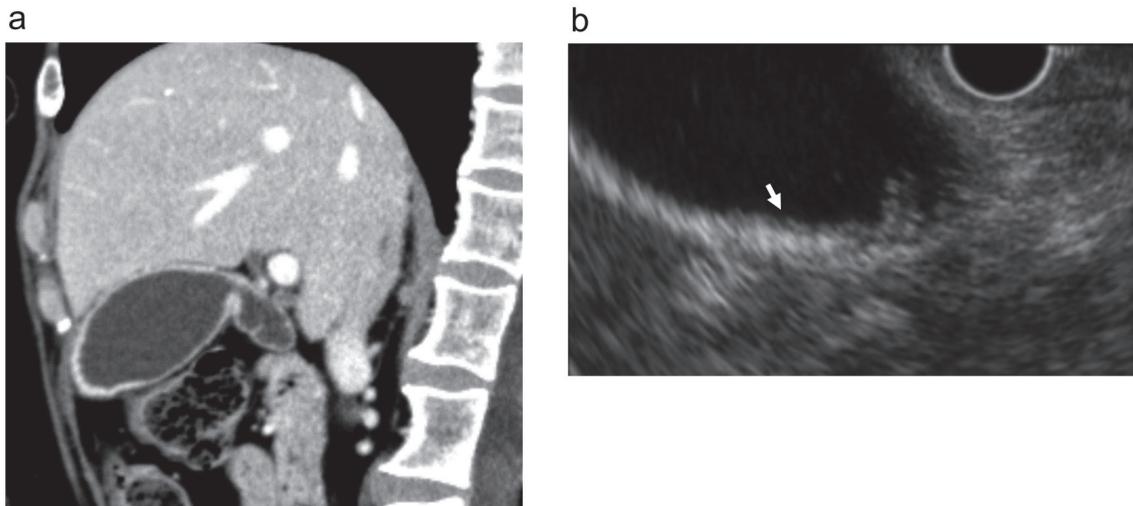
Thickening of the gallbladder wall was observed by computed tomography (a) and endoscopic ultrasonography (arrow) (b).
